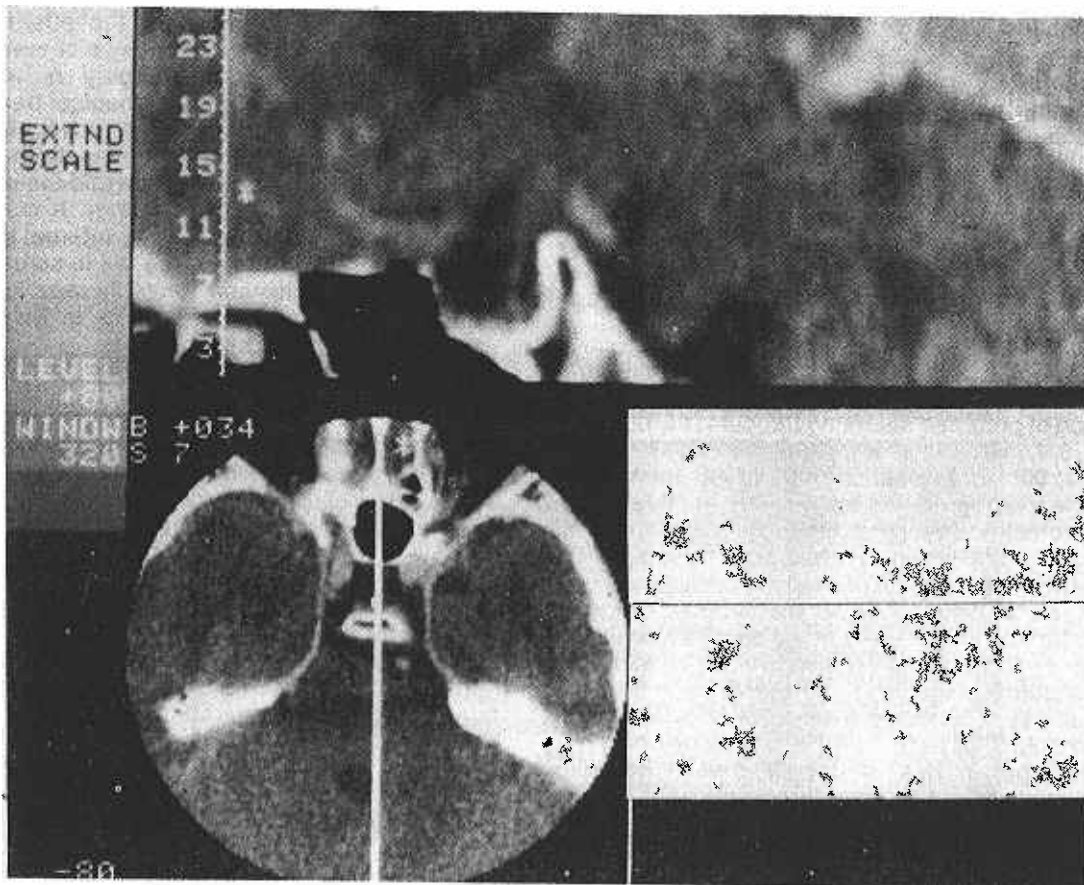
Sagittal and coronal reconstruction of a CT scan showing the empty sella syndrome.
